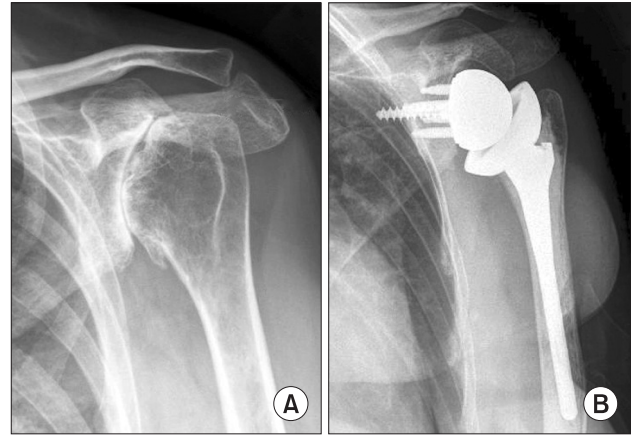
A 47-year-old female patient with rheumatoid arthritis. (A) Preoperative conventional anteroposterior radiograph of the shoulder shows severely eroded articular surfaces of glenoid and humeral head. (B) Conventional anteroposterior radiograph of the shoulder at 4 months' follow-up shows a well-fixed prosthesis.
